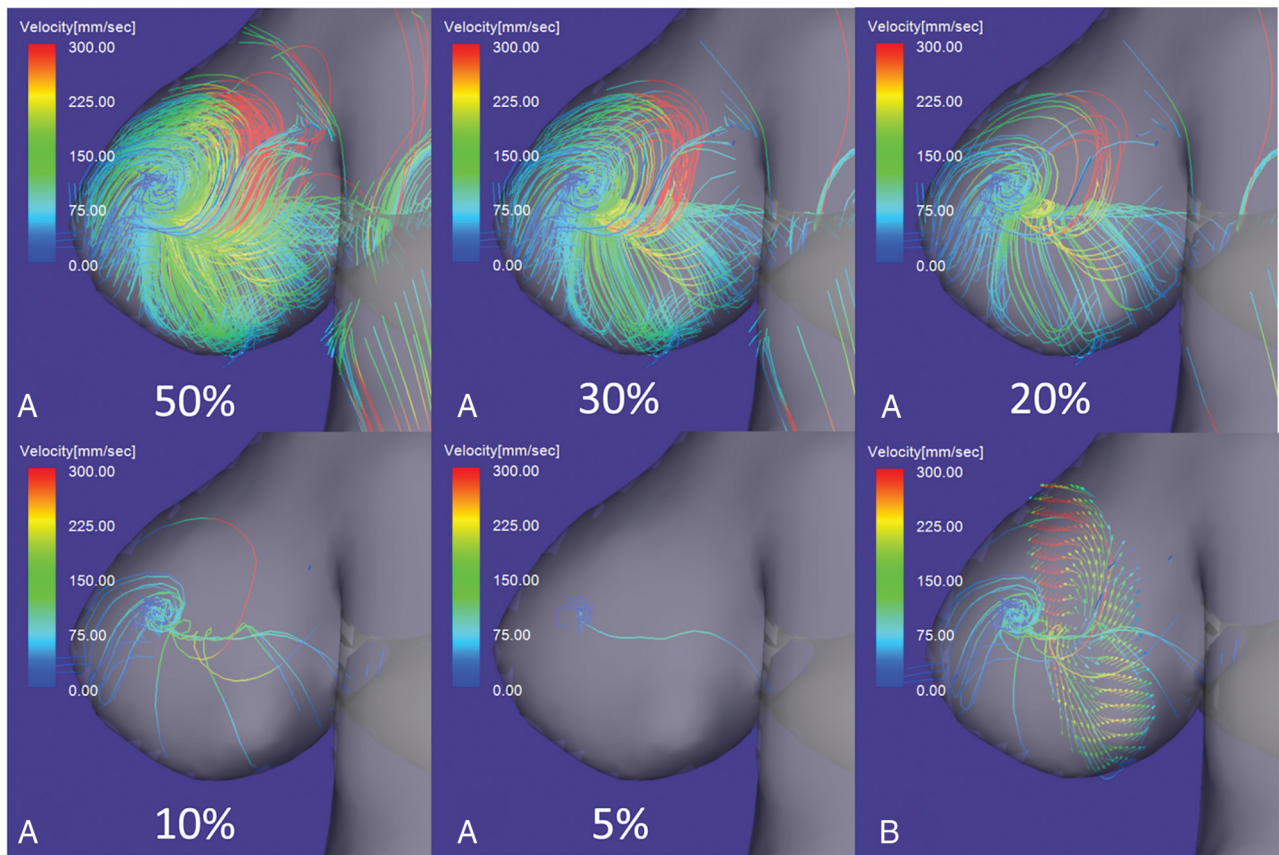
4D flow MR images of flow streamlines with velocities below the threshold determined by the percentage value of the maximum inflow velocity. *A*, When the threshold was decreased from 30% to 10% of the maximum inflow velocity, a single vortex core was visualized as a thin, streamline bundle. At a threshold of 5%, the vortex core was a single line. *B*, A thin, streamline bundle passed through the center of vortical flow vectors on a cutting plane of the aneurysm dome.
